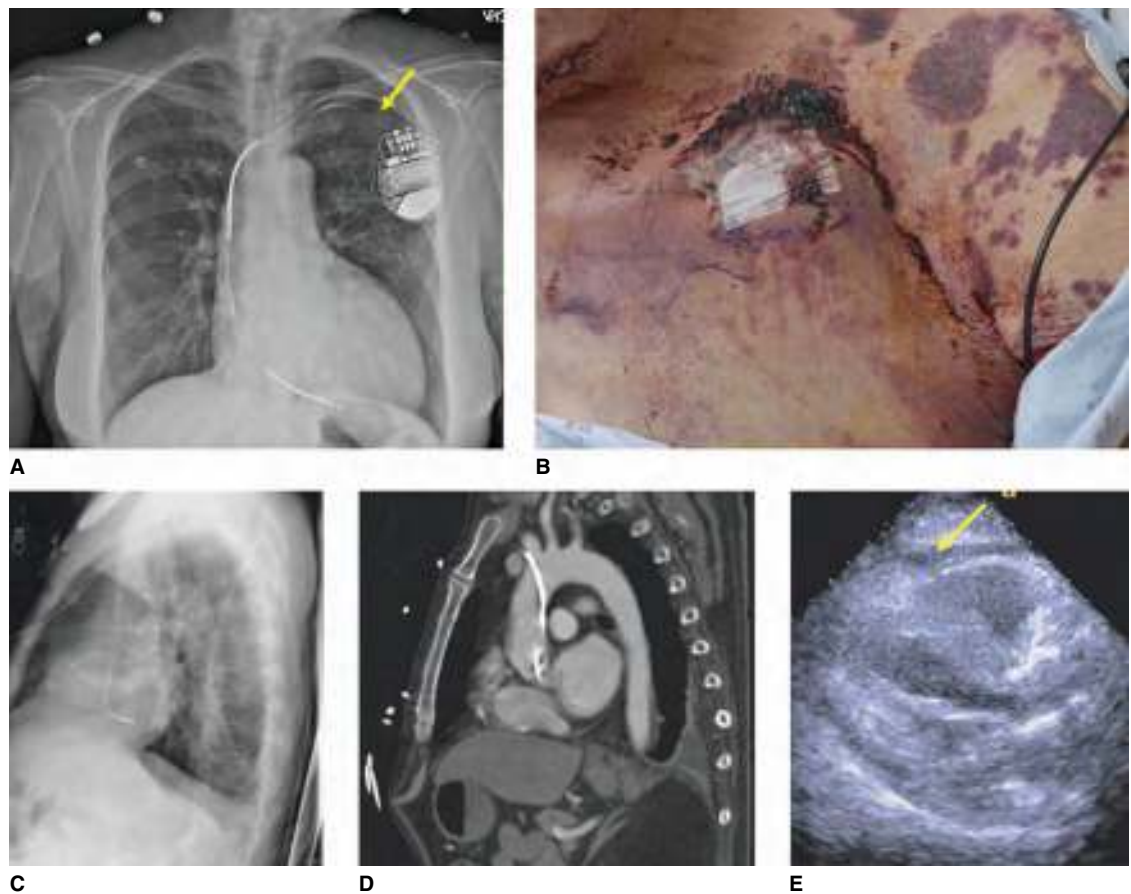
Short-term complications associated with pacemaker implantation. A. Pneumothorax. The arrow highlights the border of the collapsed lung. B. Hematoma and ecchymosis. C. Chest radiograph of arterial placement of pacing lead. The lead is pointed posteriorly while traveling through the ascending aorta. D. CT image of figure C. E. Acute pericardial effusion (arrow) after right ventricular lead implantation. (Used with permission from reference 7.)
